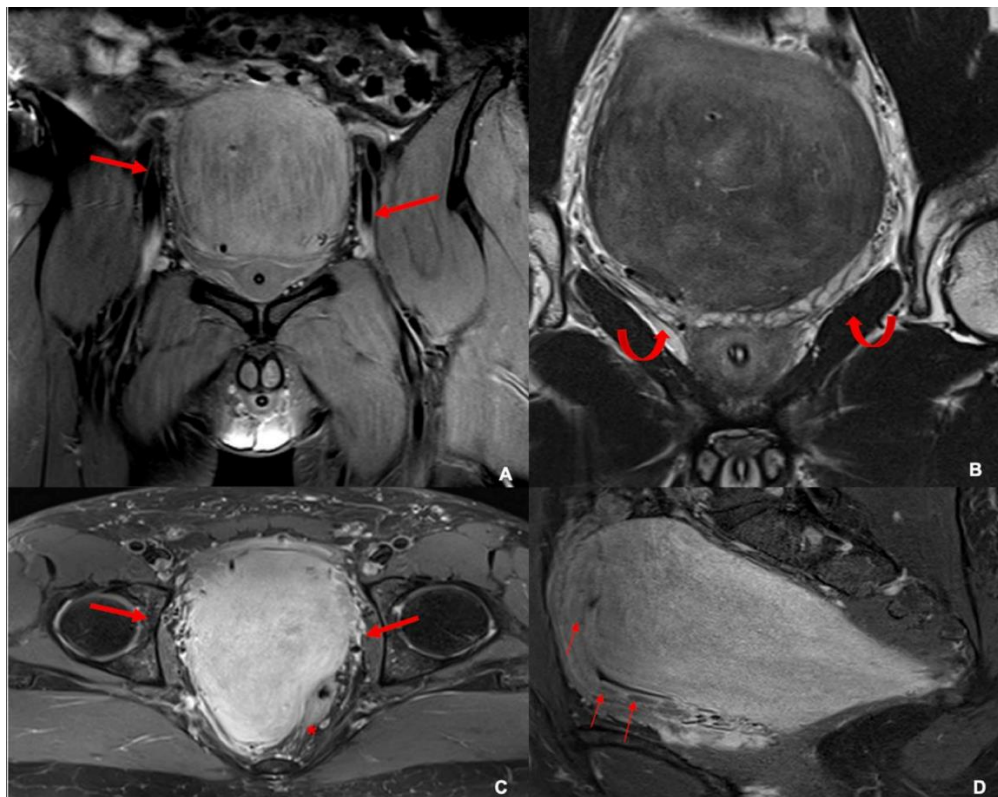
Abdominopelvic MRI.
